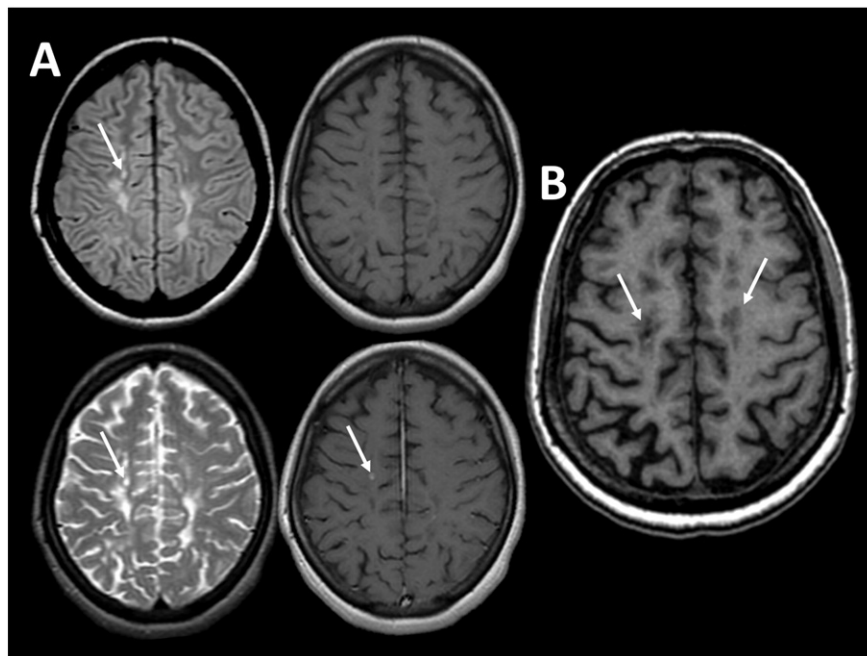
A: Axial MRI scans through the centrum semiovale in a 40-year-old woman with relapsing-remitting MS, obtained in 1994. Top-left: proton density-weighted; bottom-left: T2-weighted; top-right: T1-weighted; bottom-right: T1-weighted after intravenous administration of gadolinium-based contrast material. The arrows point to a lesion that enhances following contrast administration, meaning that it is bright on the post-contrast T1-weighted image. It is invisible on the pre-contrast T1-weighted image. B: Axial 3D T1-weighted scan from the same individual 8 years later. Note the degree to which lesions (arrows) are visible as hypointense foci on this type of T1-weighted image relative to the 2D spin-echo image in panel A (top-right). Note also the inhomogeneity of the signal within each of the lesions, suggesting differential sensitivity to intralésional pathological processes.
